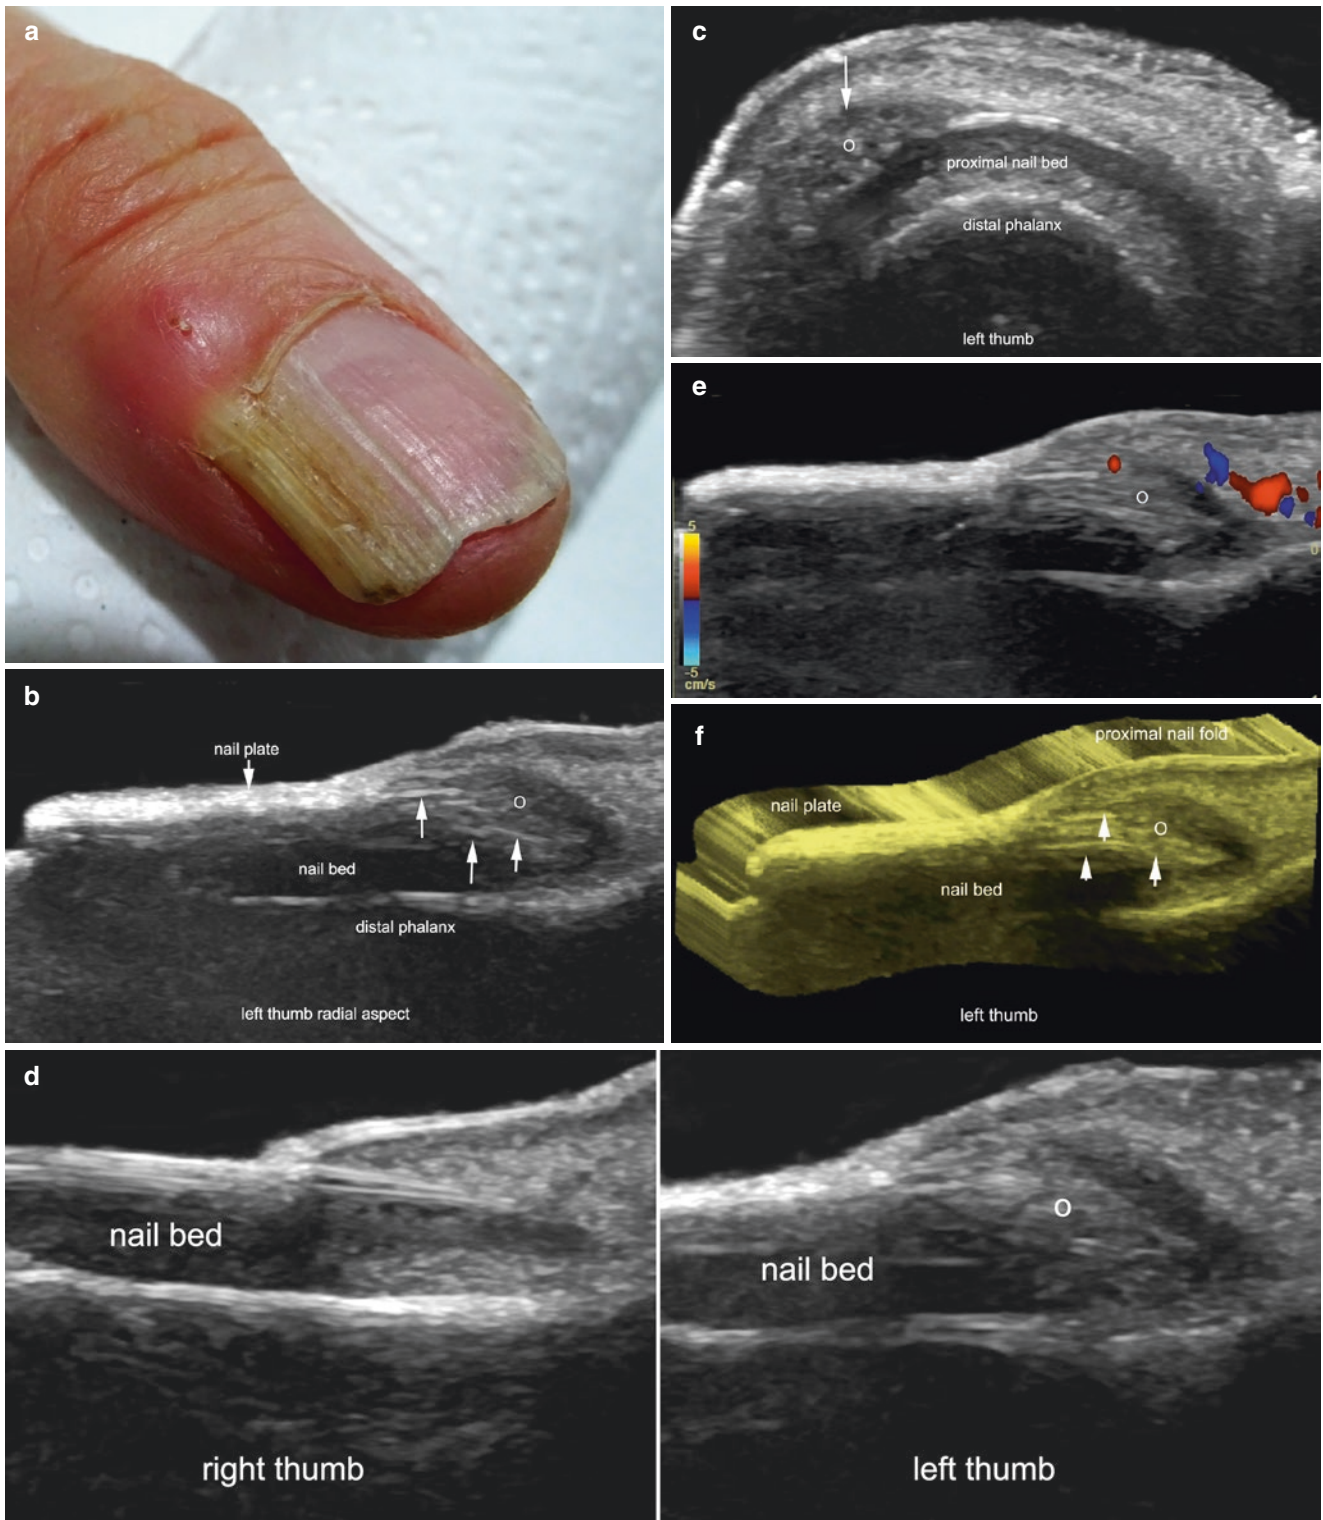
Onychomatricoma. (a) Clinical image of the nail of the left thumb. (b–f) Ultrasound images (b–d, greyscale; b, longitudinal view; c, transverse; d, comparison right to left, longitudinal; e, color Doppler, longitudinal; f, 3D reconstruction, longitudinal) demonstrate
